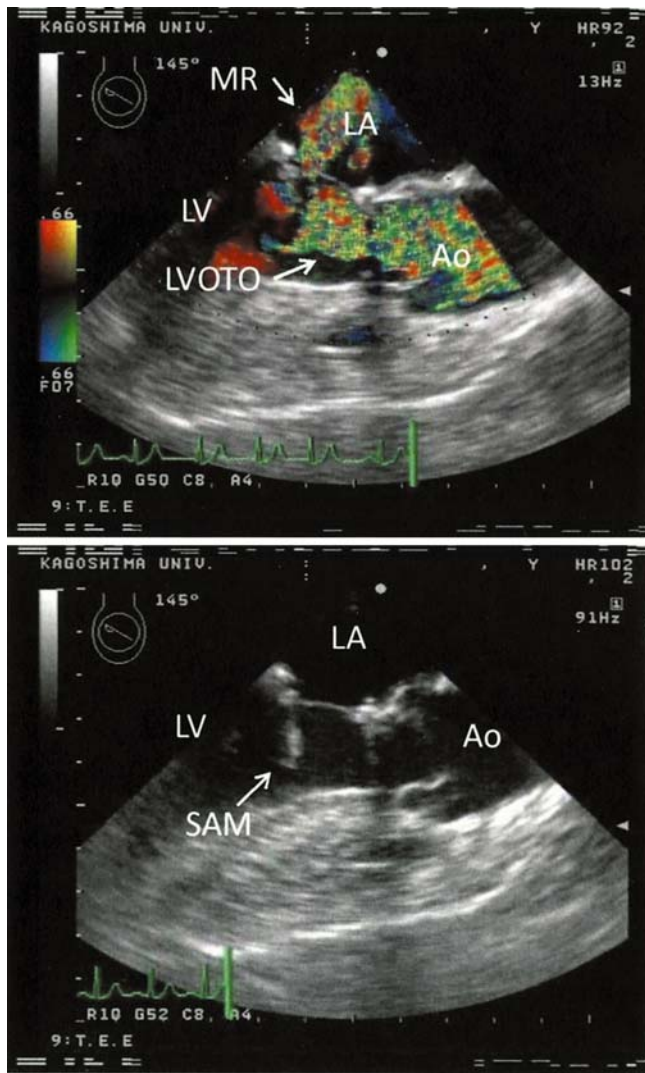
Transesophageal echocardiography mid-esophageal long-axis view before landiolol hydrochloride administration, showing systolic anterior motion (SAM), left ventricular outflow tract obstruction (LVOTO), and mitral regurgitation (MR). LA, left atrium; LV, left ventricle; Ao, aorta
